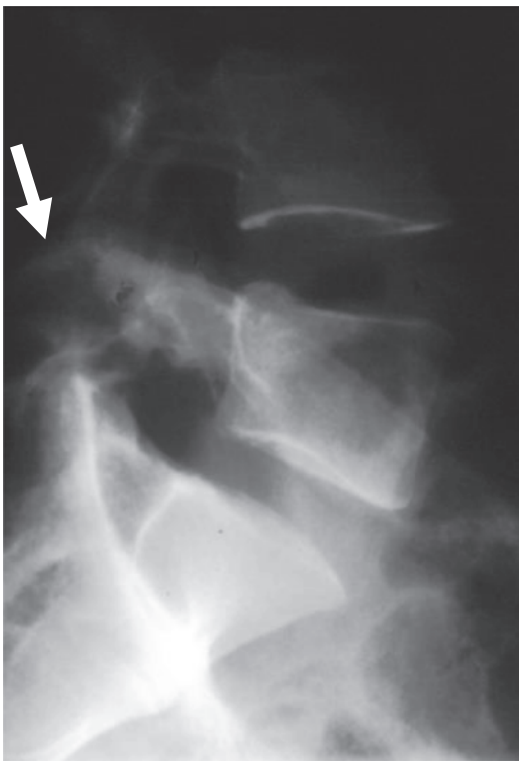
Neural arch tuberculosis. Lateral radiograph of the lower lumbar spine shows osteolysis of L5 neural arch (arrow)
